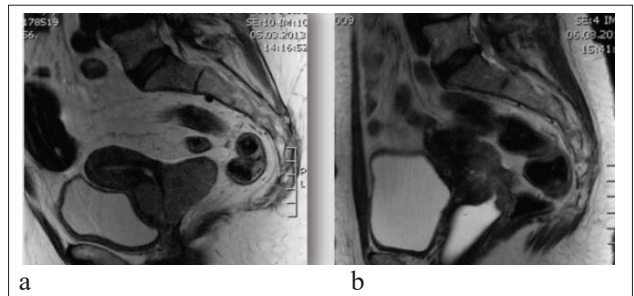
MRI-T2w sag: a. FIGO IIB b. FIGO IVA
